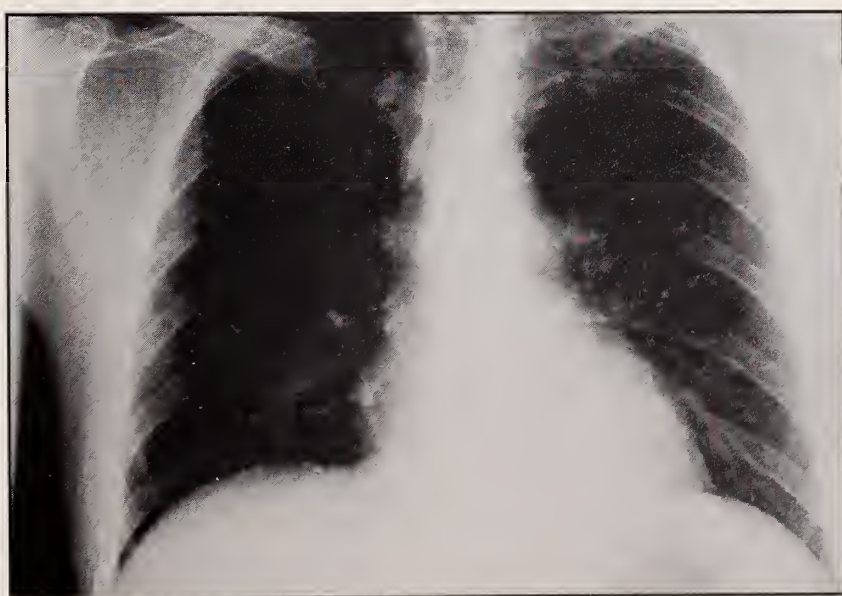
Mycobacterium avium-intracellulare*. Radiographically, indistinguishable from *Pneumocystis*.
